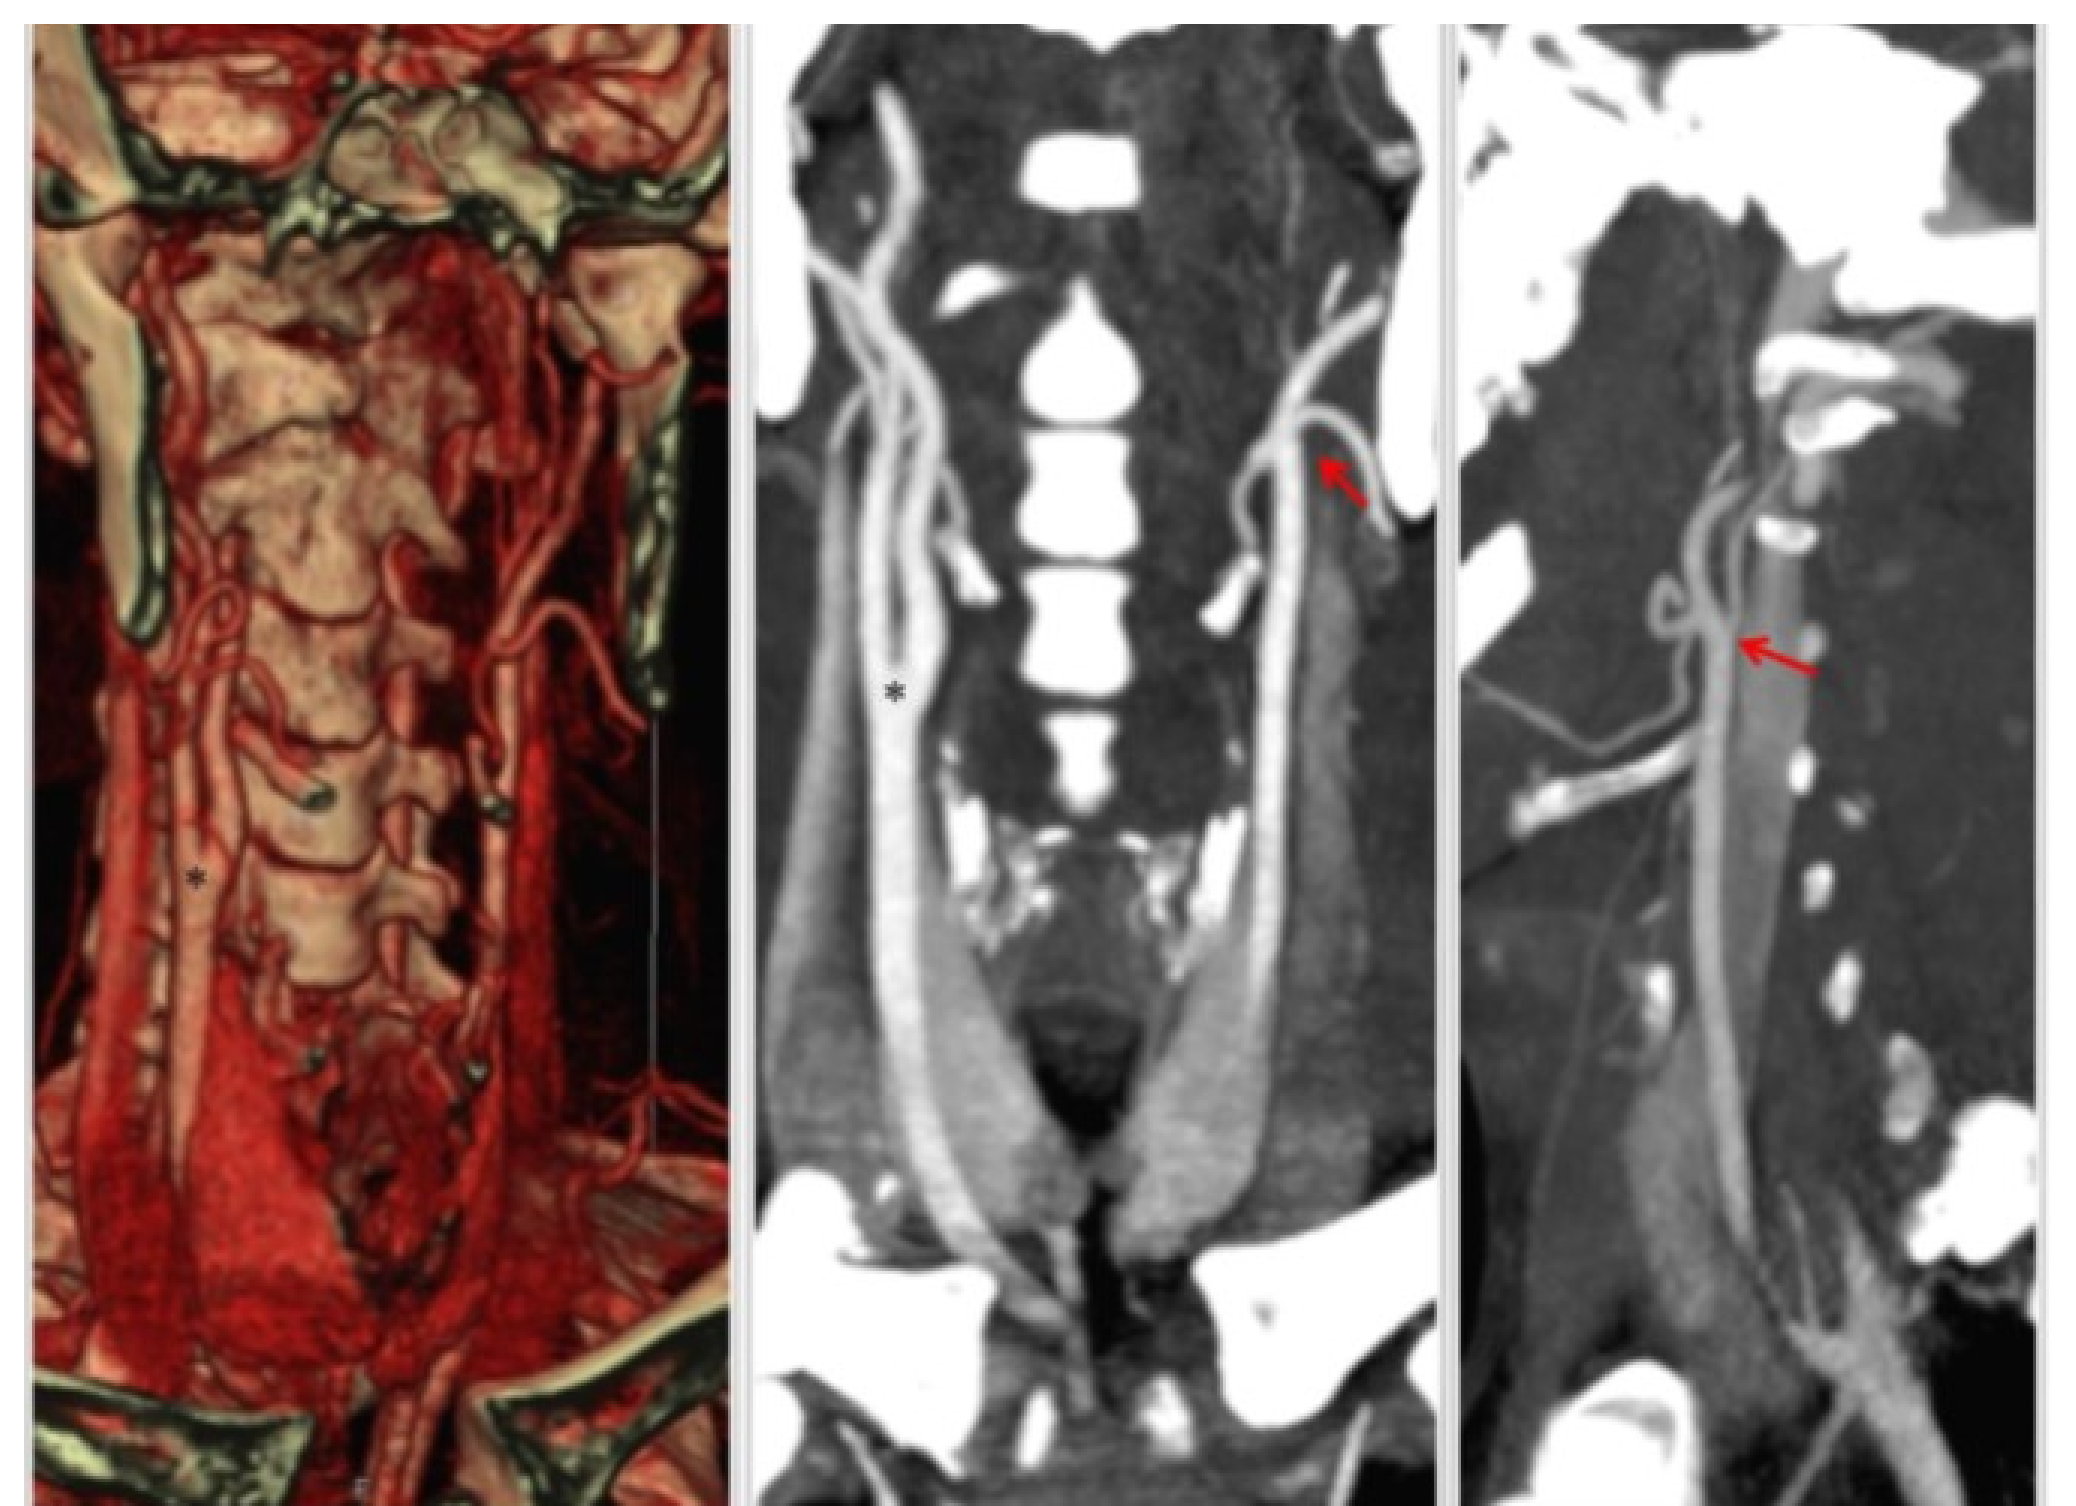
CT Angiography with Volume Rendering Technique (VRT) [a] and Maximum Intensity Projection (MIP) [b,c] well depicted the normal carotid artery bifurcation on the right side (asterisks) and the complete absence of the cervical and intracranial left ICA with left common carotid artery continuing as external carotid artery (red arrows)
